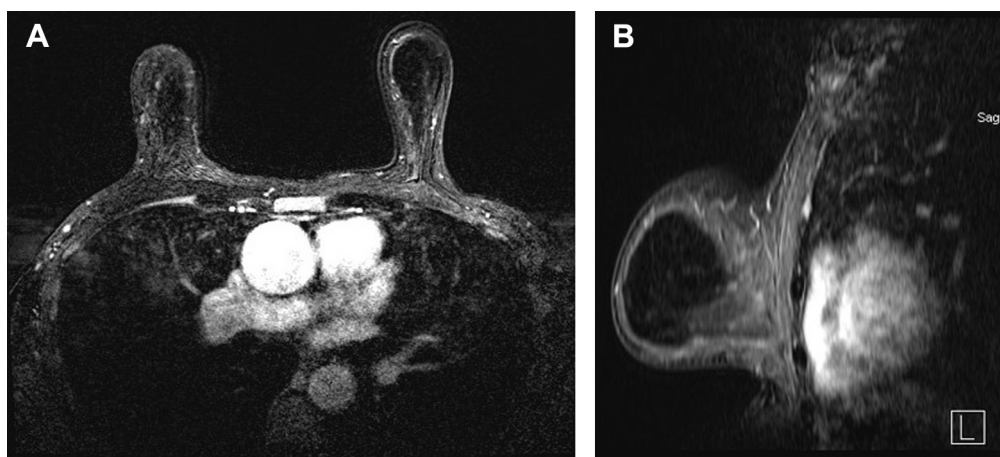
Contrast-enhanced bilateral breast MRI. (A) axial and (B) sagittal images following the removal of the bilateral breast implants and resection of the fibromatosis of the left breast reveals no residual abnormal areas of enhancement at the site of the tumor in the left chest wall or breast.
